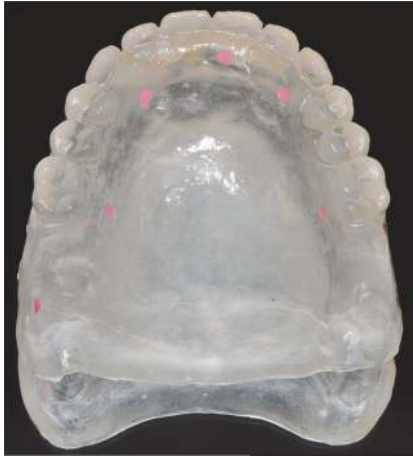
Radiographic template in transparent acrylic resin with gutta-percha markers.
